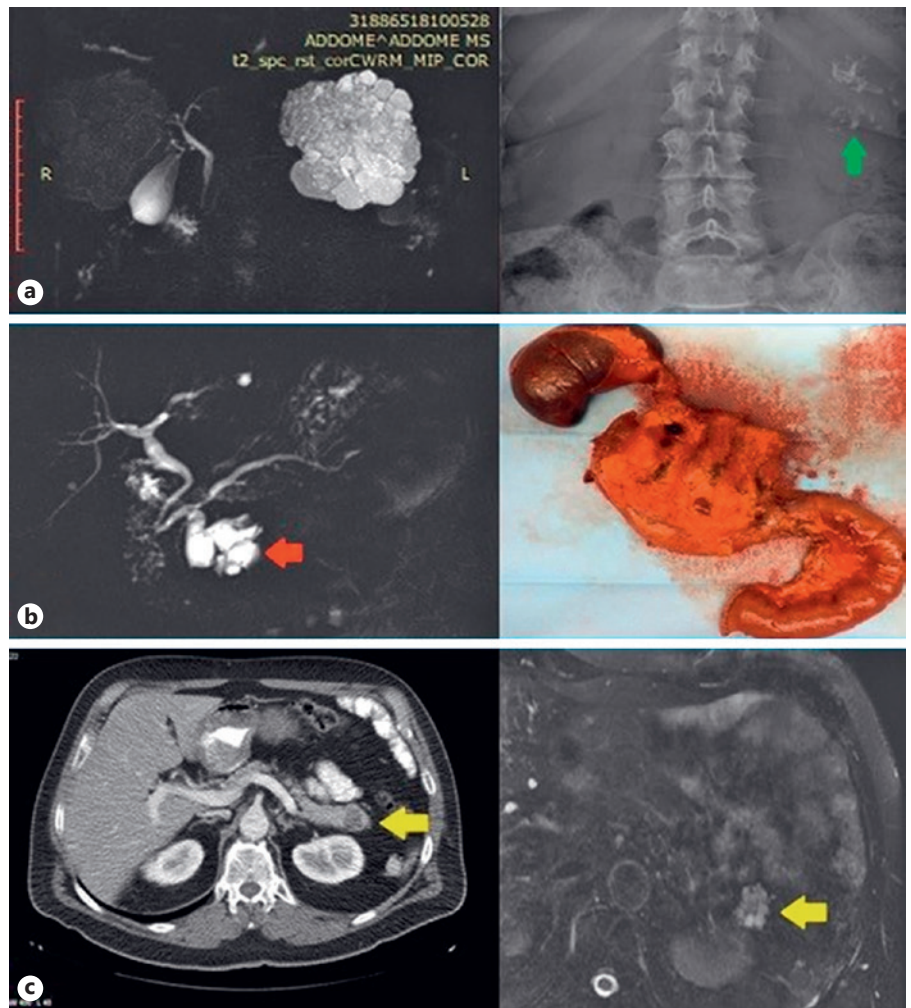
“The good, the bad, and the ugly”. a The good: asymptomatic, big serous cystadenoma of the pancreatic tail (micro-macrocytic type, with typical big central scar and calcifications) incidentally found in a middle-aged woman. Incidental diagnosis was due to calcification resulting from abdominal X-Ray (green arrow). b The bad: a 4-cm cystic lesion of the pancreatic head, with a solid enhancing component and initial retro-dilation of common bile duct and MPD (red arrow). Final pathology after PD revealed and invasive ductal adenocarcinoma arising in BD-IPMN (the IPMN showed an intestinal phenotype with high grade dysplasia adjacent to the invasive component). c The ugly: a 2.5-cm cystic lesion in the pancreatic tail (yellow arrow) with multiple small enhancing septations was associated to an enhancing solid component reported at EUS (a “high risk stigmata” [11]). Final pathology after surgery revealed a “harmful”, microcystic serous cystadenoma.
